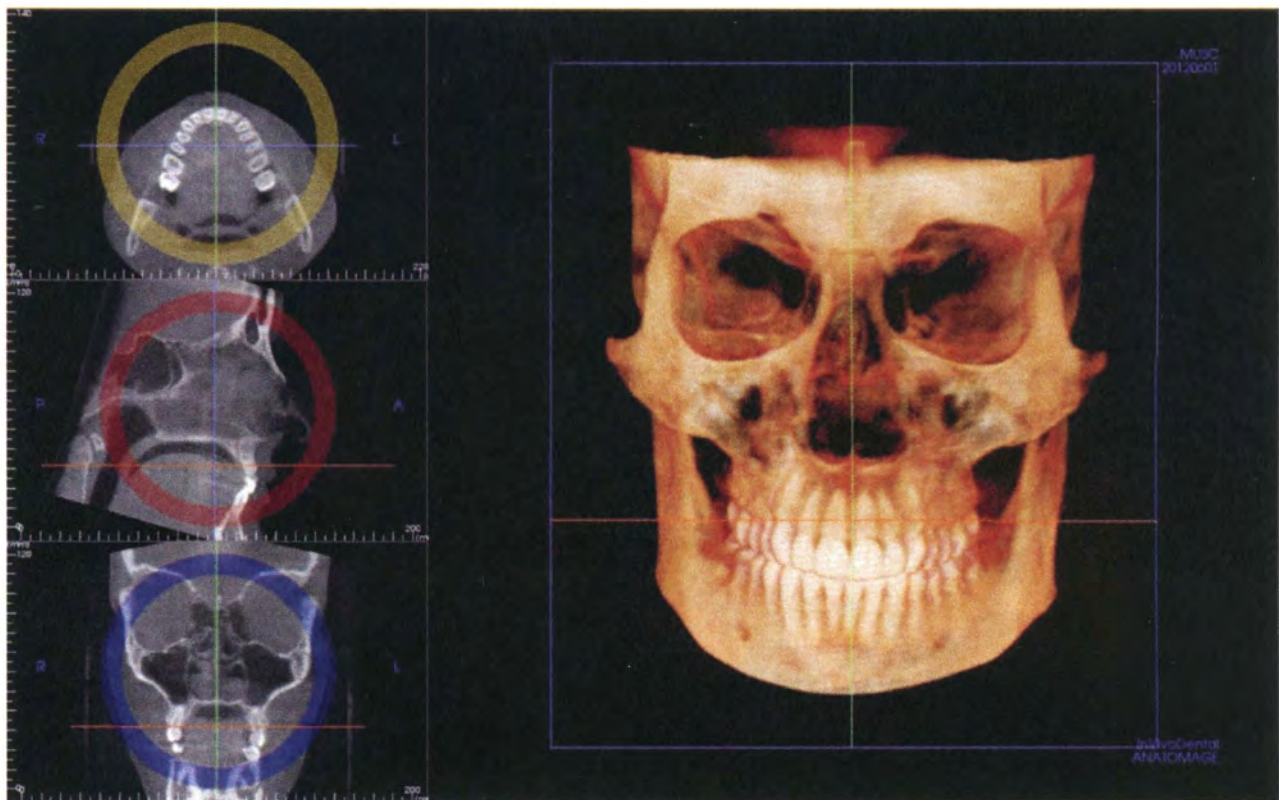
CBCT orientation in coronal view. This is the view utilized in step 1 of the orientation process for each CBCT evaluated for axial alignment along true vertical.
